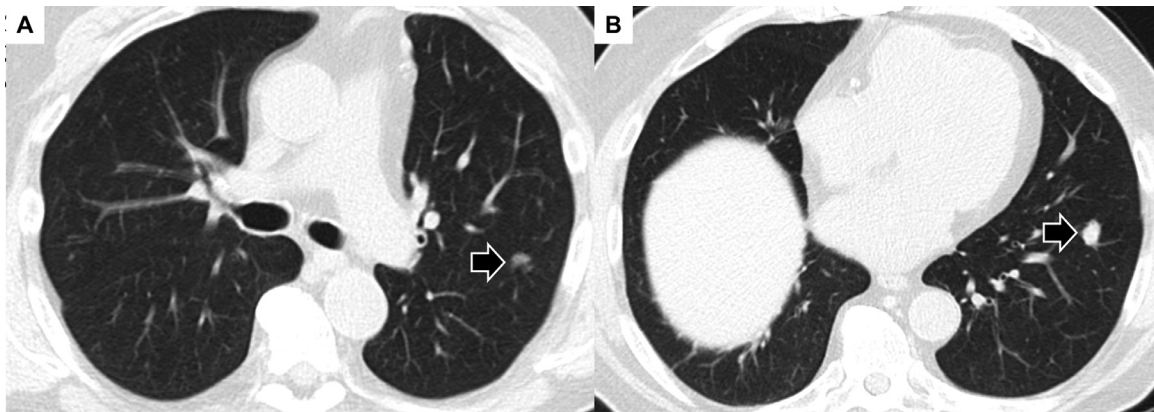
Imaging findings in a 73-year-old man with pulmonary light chain deposition disease (case 4). Axial (A and B) noncontrast chest CT slices demonstrate 2 solid lobulated pulmonary nodules (arrows) with a middle craniocaudal distribution in the left upper and left lower lobes.
